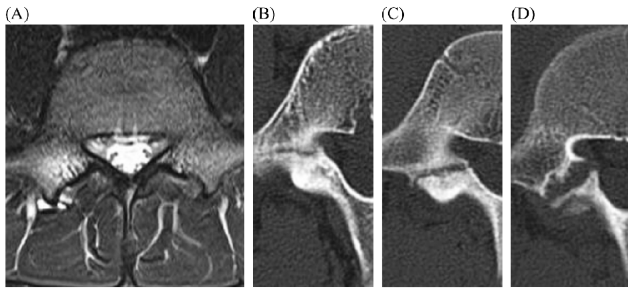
Computed tomography (CT) classification of pediatric lumbar spondylolysis, as reported by Fujii *et al.* and Sakai *et al.* Stress reaction on MRI, no fracture line CT (A) A hairline fracture is visible in the early stage (B), a clear bone gap is apparent in the progressive stage (C), and pseudarthrosis occurs in the terminal stage (D). MRI, magnetic resonance imaging ; CT, computed tomography
